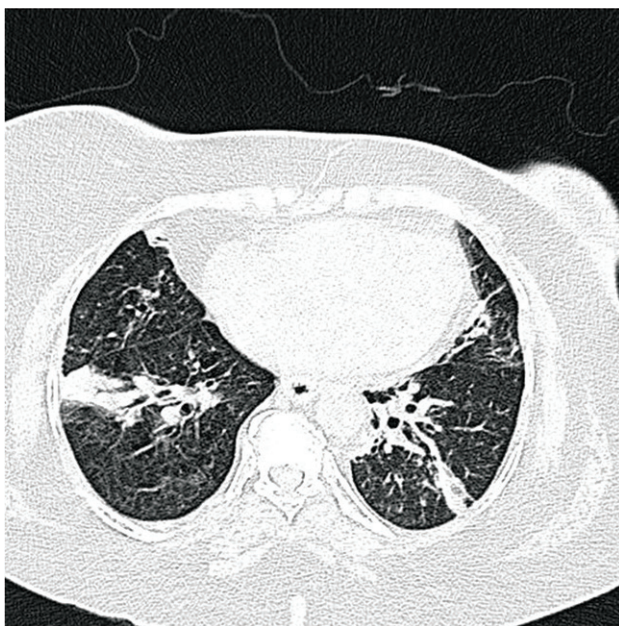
HRCT chest lung window showing bilateral areas of patchy consolidation
